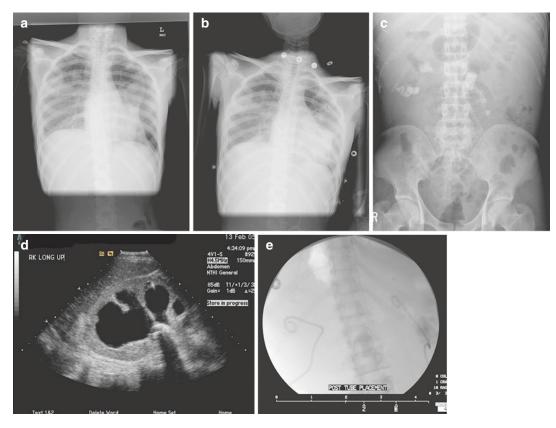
(a) Frontal portable chest radiograph in a patient with "tsunami lung" reveals left pneumothorax with air space consolidation and cavity formation [16]. (b) Frontal portable chest radiograph following left pigtail tube thoracostomy placement. (c) KUB reveals multiple
